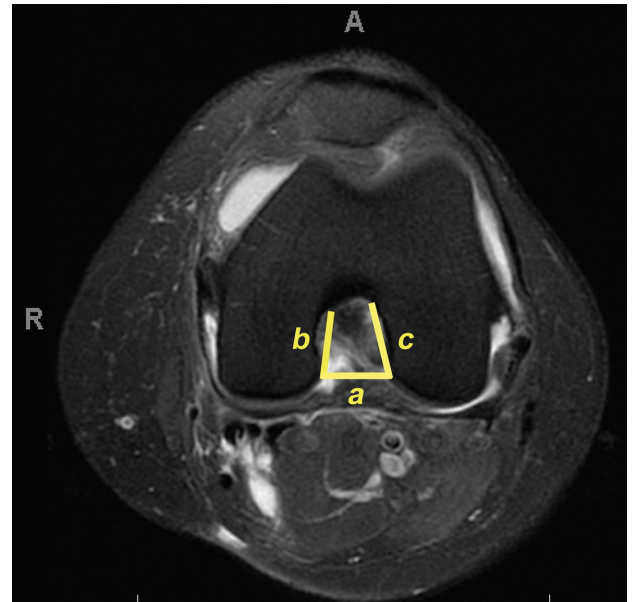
T2-weighted axial magnetic resonance imaging scan of a right knee showing a – the notch width at the base, b – the medial wall height, and c – the lateral wall height. After measuring the height of the lateral and medial walls of the notch, the mean height was calculated. This number was then divided by 3 to obtain the height increment at which one-third and two-thirds midnotch width measurements should be taken. Notch width was calculated at each interval and then averaged to obtain the mean notch width. A, anterior; r, right.
